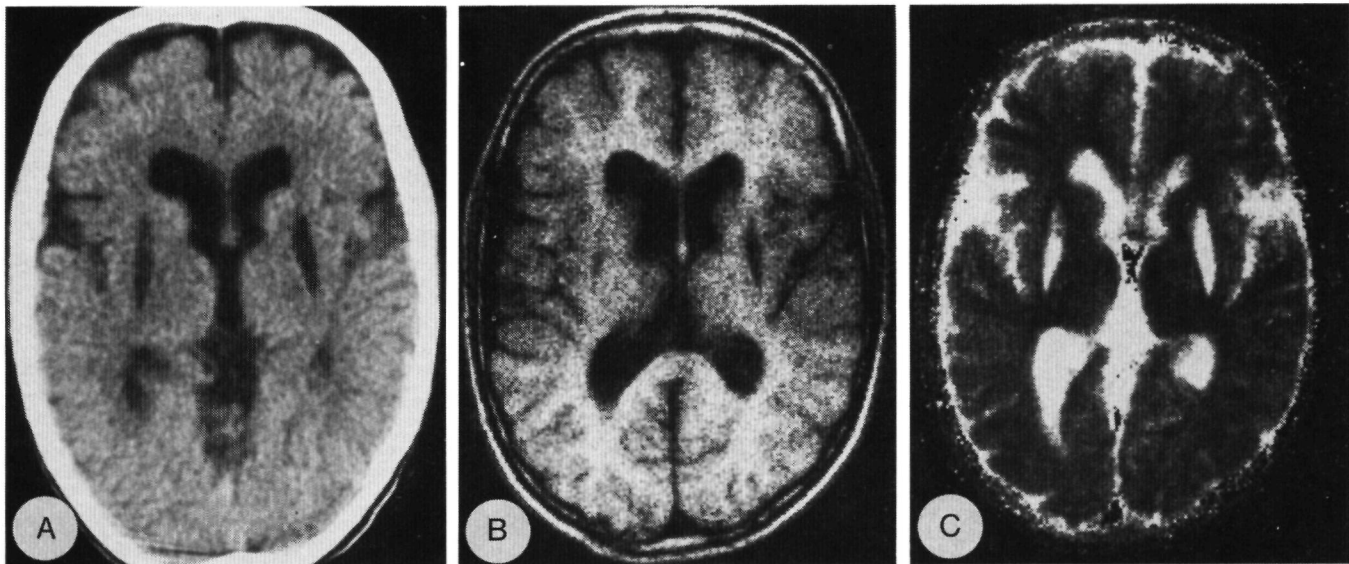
(Case 2). A, CT image. Hypodense areas in the putaminal regions. B, T₁-weighted image (SE: TE 30 ms, TR 400 ms). Hypointensive areas in the putaminal regions. C, calculated T₂ image. Hyperintensive areas in the putaminal regions.
